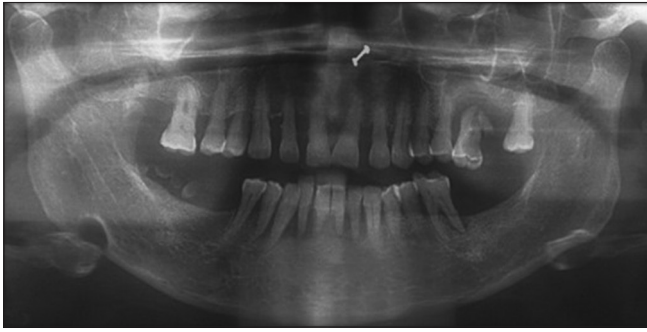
Panoramic radiograph showing well-defined unilocular radiolucency
